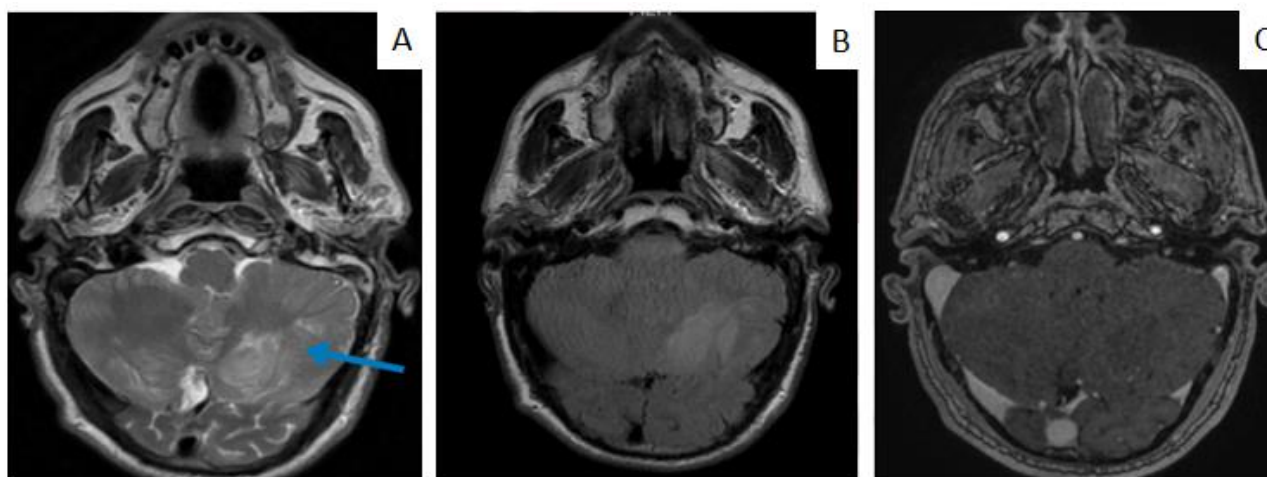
Axial MRI of the brain showing lamellar lesions (blue arrow), A: in T2 sequence, B: in FLAIR sequence, C: after contrast agent injection
